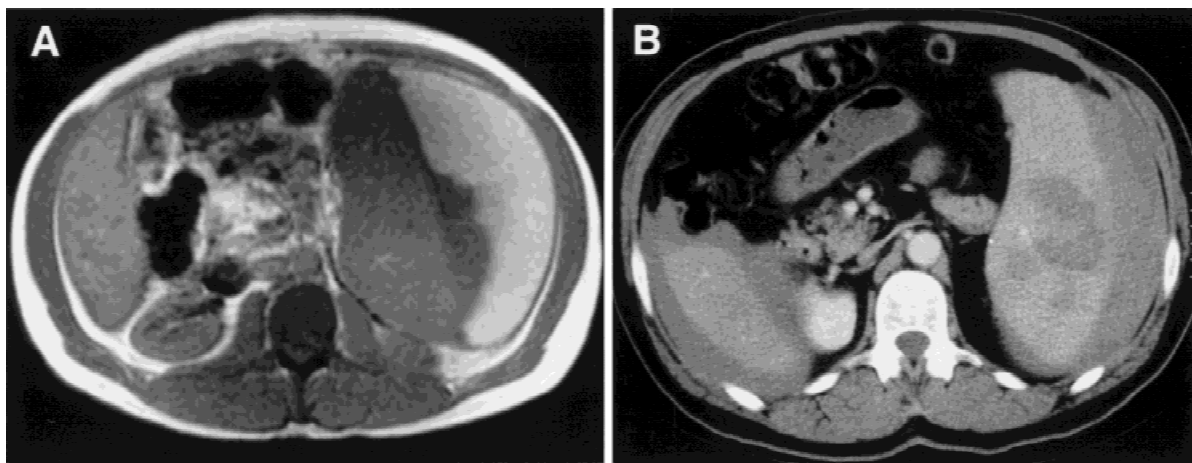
(A) T1-weighted spin echo MRI image of the upper abdomen of case 1 demonstrating an enlarged spleen with a large hyperintense subcapsular hematoma. (B) CT scan of the upper abdomen of case 2 demonstrating a subcapsular splenic collection of blood, with hemorrhage also seen around the tip of the liver.
